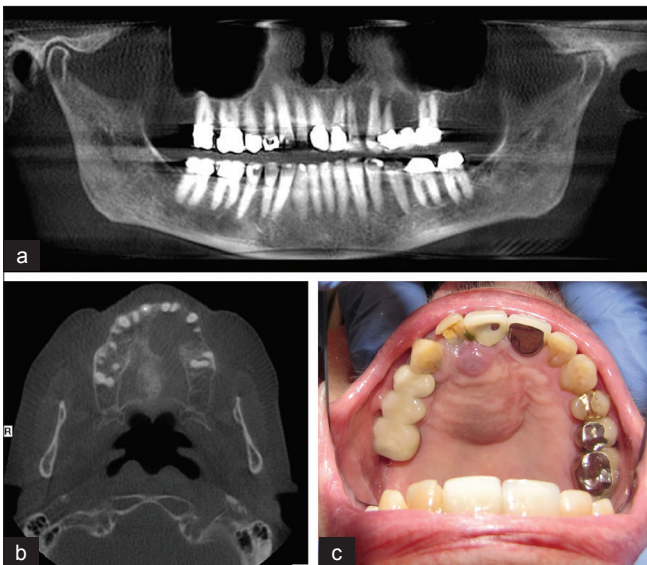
A radiograph of a central giant cell granuloma of the anterior maxilla in a 94-year-old male (a) Appearance on panorex radiograph. (b) Appearance on axial CT scan. (c) Clinical appearance. The lesion was locally enucleated
